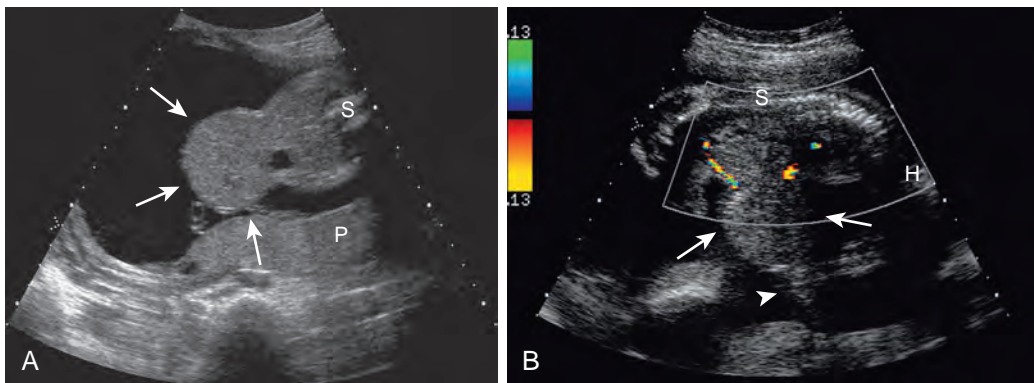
Omphalocele. A. Transverse prenatal ultrasound image demonstrates the liver herniating through an anterior abdominal wall defect (arrows) in a fetus with an omphalocele. B. Sagittal image also demonstrates the eviscerated liver (arrows), with the umbilical cord inserting into the membrane containing the liver (arrowhead). H, Head; P, placenta; S, spine.
